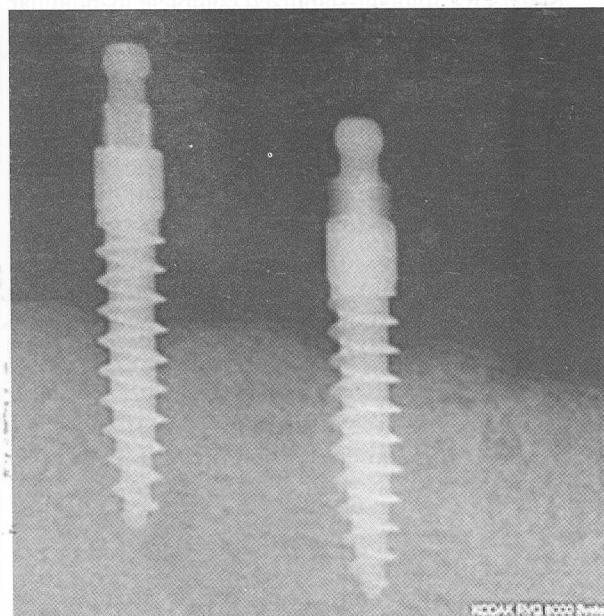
Periapical radiographs showing mini implants at lower left quadrant 20 months post-loading. There is an increase in peri-implant marginal bone loss of approximately one to two threads from the time of insertion.
